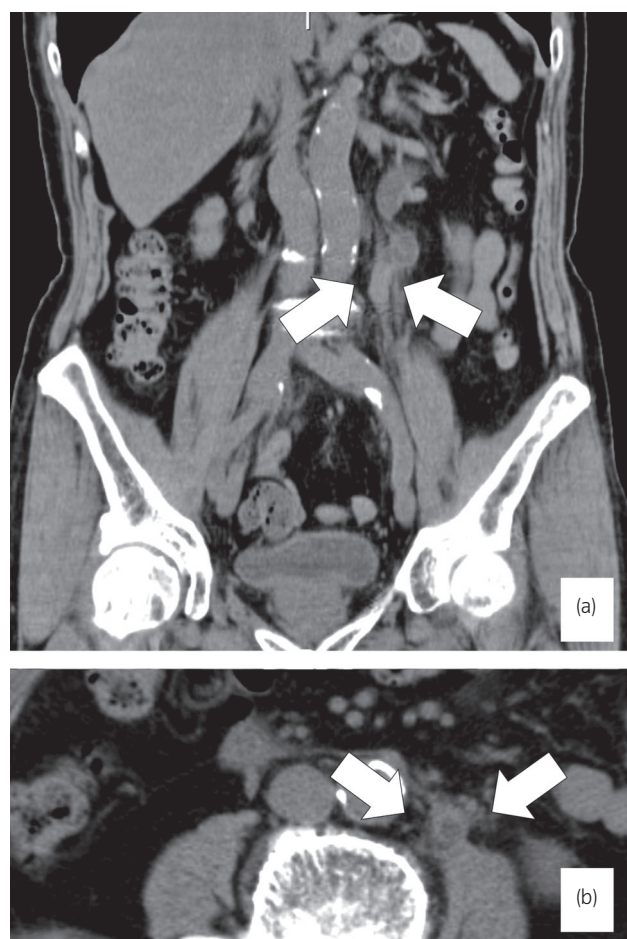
Abdominal CT image showing a left ureteral mass (arrows) causing hydronephrosis. (a) Coronal view. (b) Axial view.
